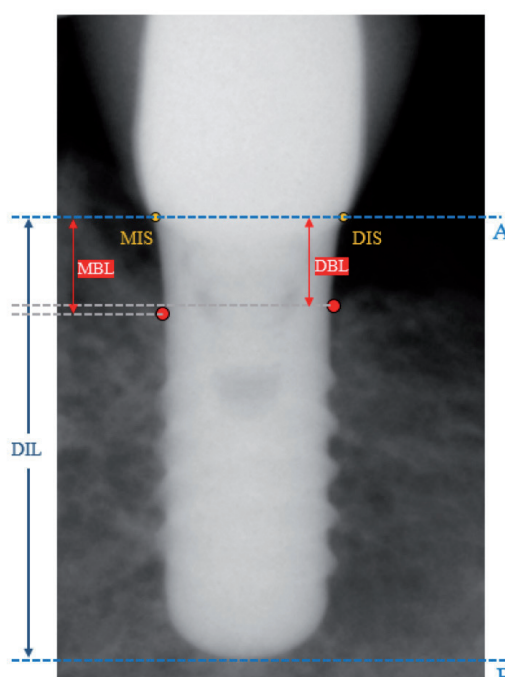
Radiographic analysis applied on tissue level implants.
